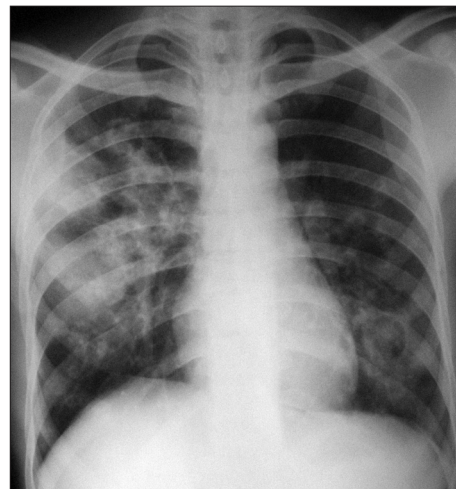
Chest X-ray shows bilateral pulmonary infiltrates (right > left), with ill-defined cavities showing the crescent sign
